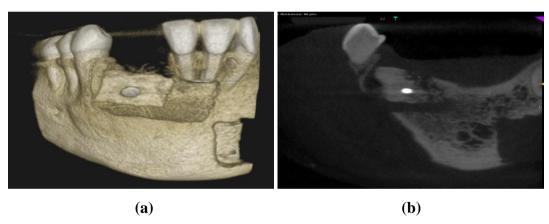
D: Post-operative CBCT - (a) 3D reconstruction showing bone graft fixed with screw in relation to 42, 43 region.
